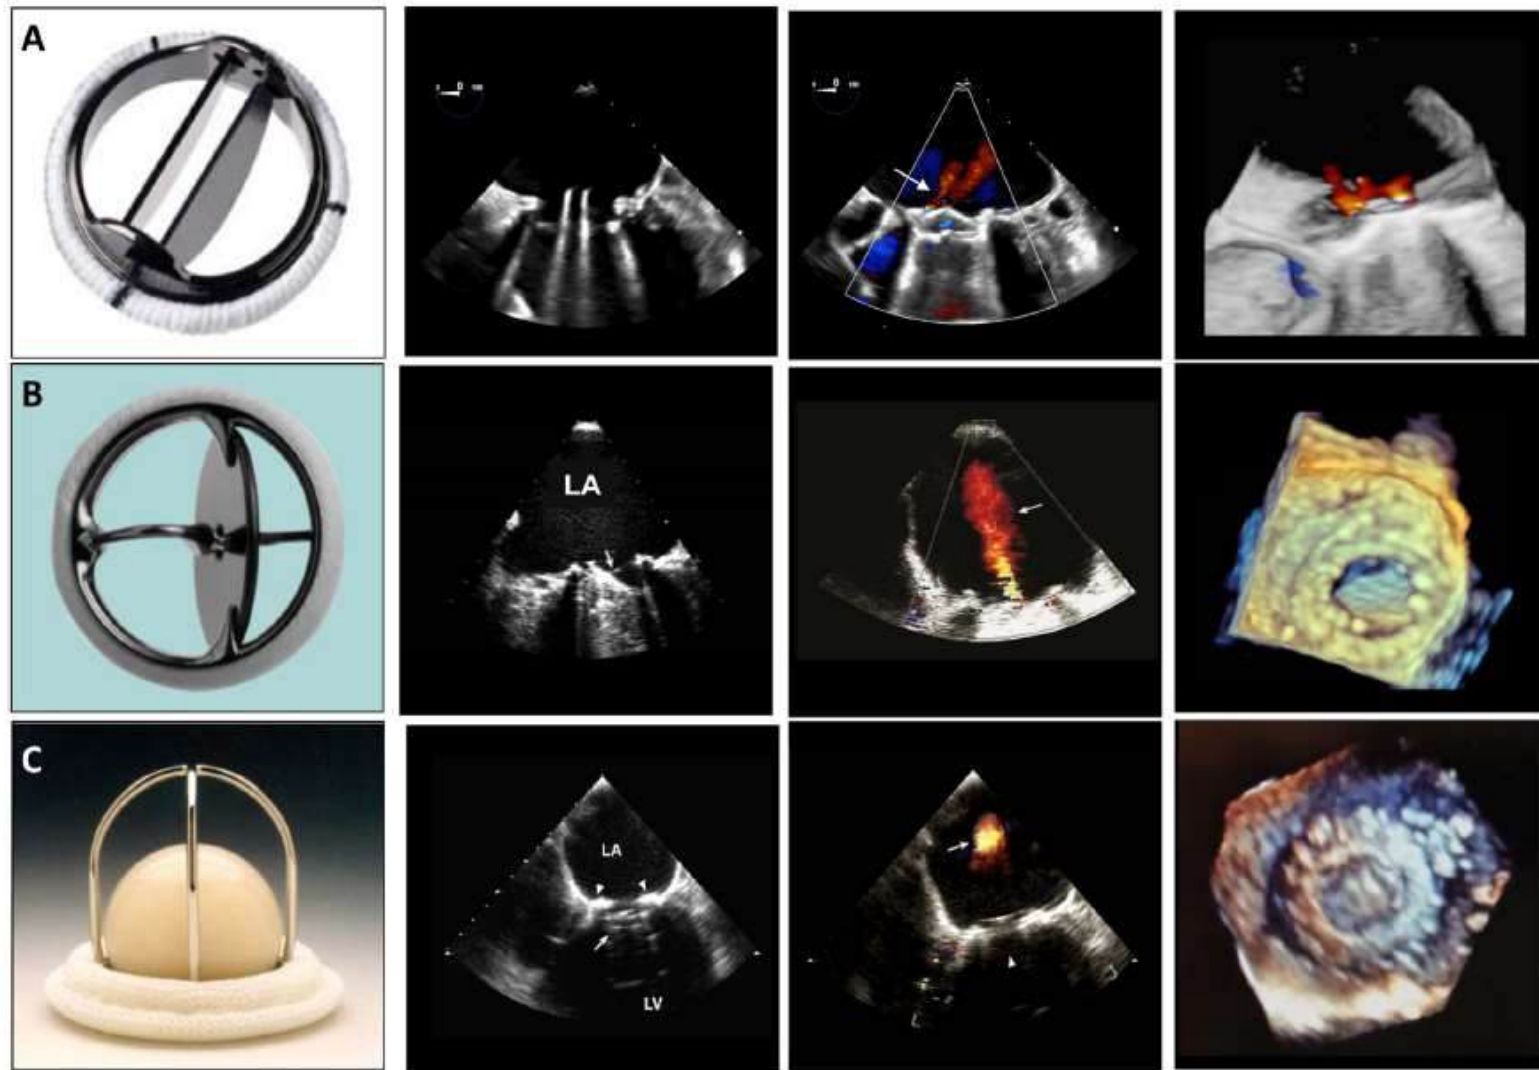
Mechanical valves: (A) bileaflet, (B) single-leaflet, and (C) caged-ball valves and their 2D and 3D transesophageal echocardiographic images. The bileaflet valve (A) is characterized by two leaflets that open and close in a coordinated manner. The single-leaflet valve (B) has a single leaflet that opens and closes. The caged-ball valve (C) features a ball within a cage that opens and closes. The 2D and 3D TEE images provide detailed views of the valve structure and its position within the heart.
